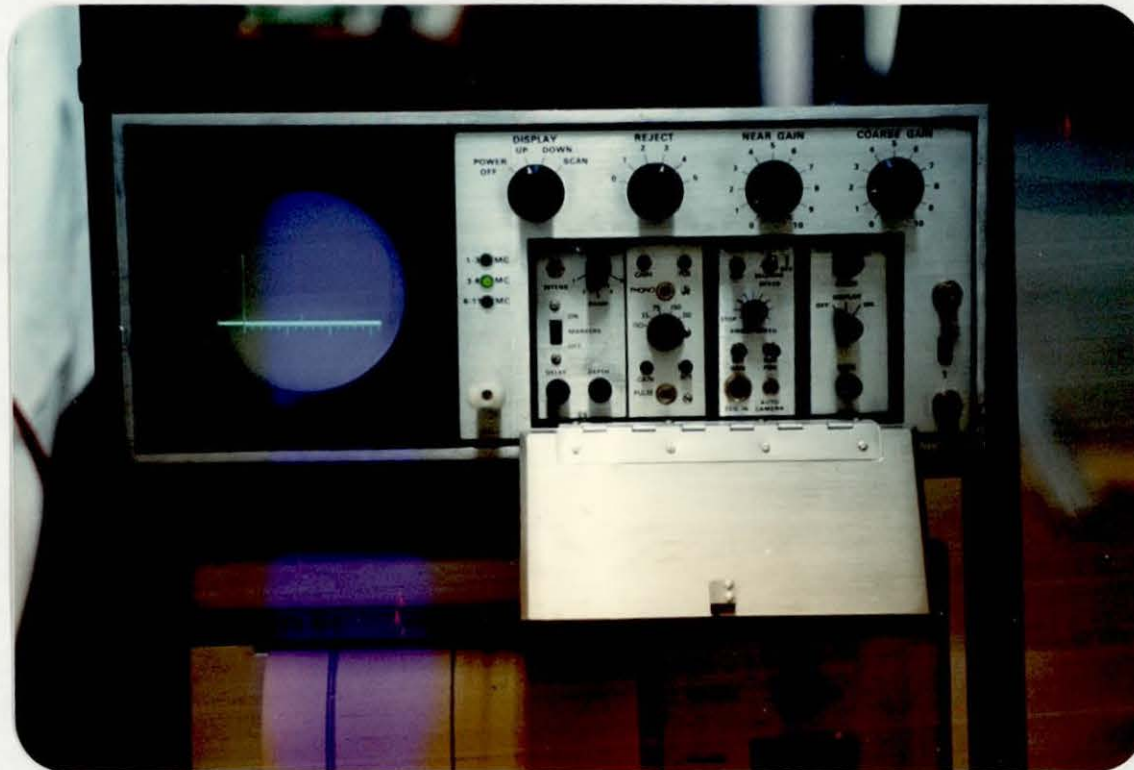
The Ekoline 20A ultrasonoscope.
